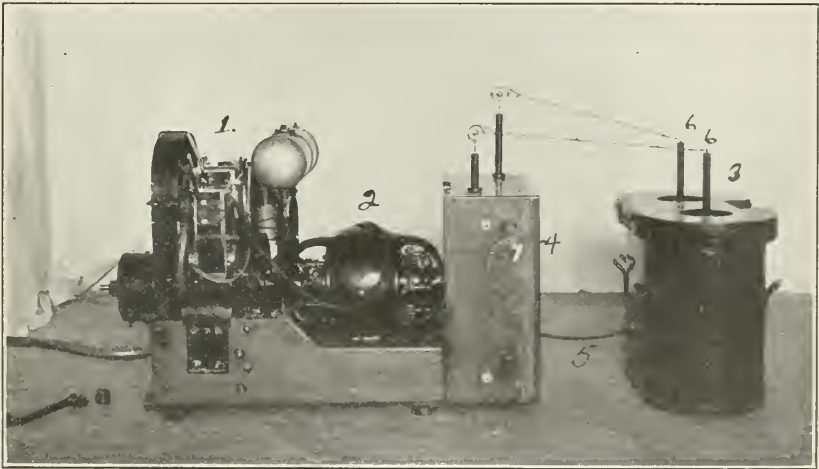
Type of field X-ray apparatus with motor-cycle engine. 1, Engine; 2, motor; 3, transformer; 4, box containing revolving rectifying switches; 5, cable containing wires for circuit from motor through primary of transformer and return; 6, secondary terminals of transformer; 7, terminals through which current is carried from rectifying switches to the X-ray tube.
